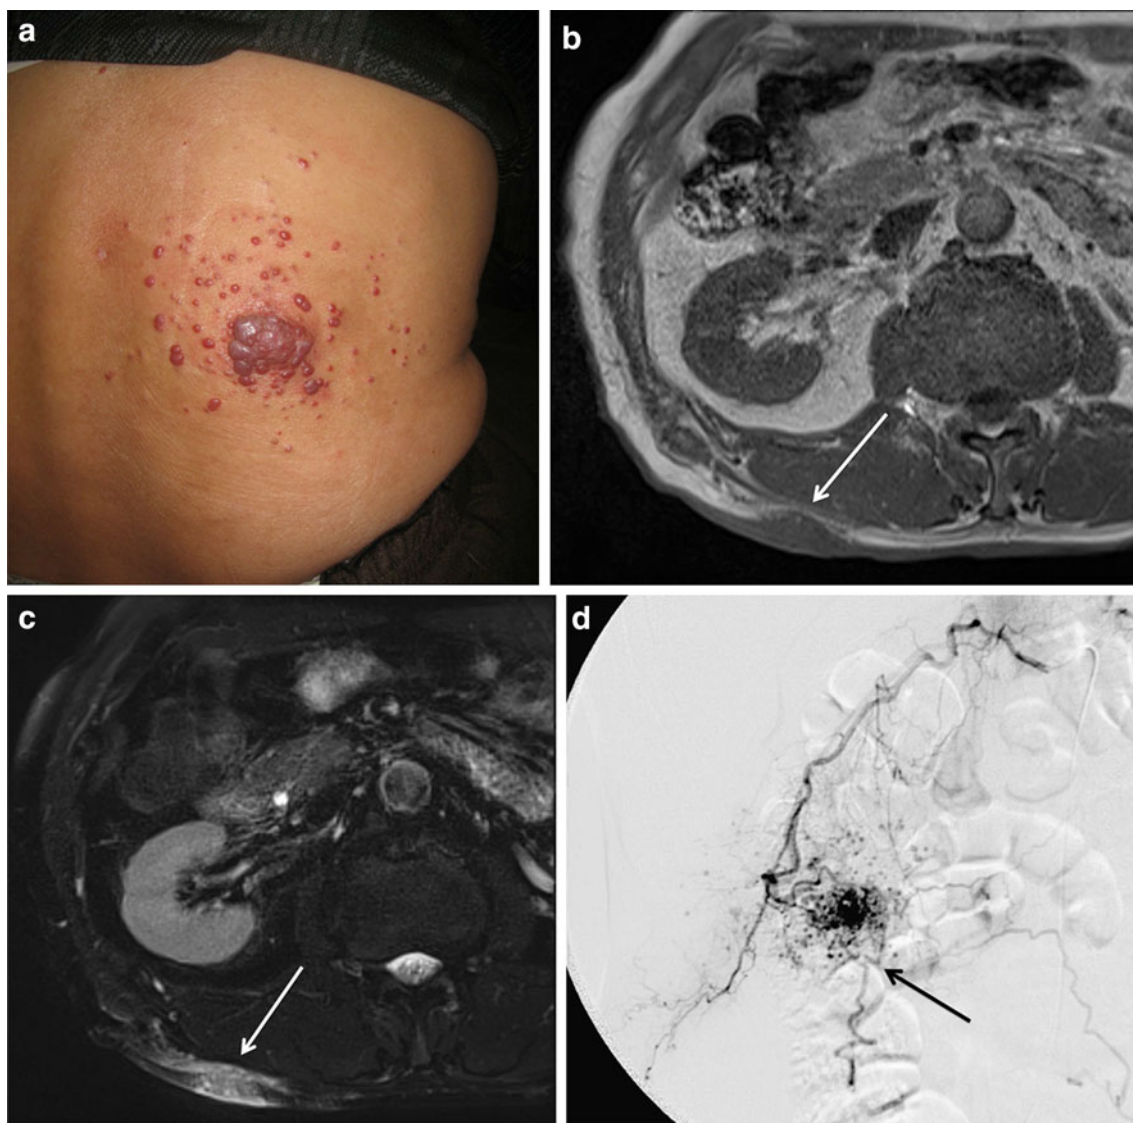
Pyogenic granuloma of the back in a 66-year-old man. a Clinical image shows multiple reddish papules. b Axial T1-weighted MR image shows a homogeneous mass isointense to muscle
